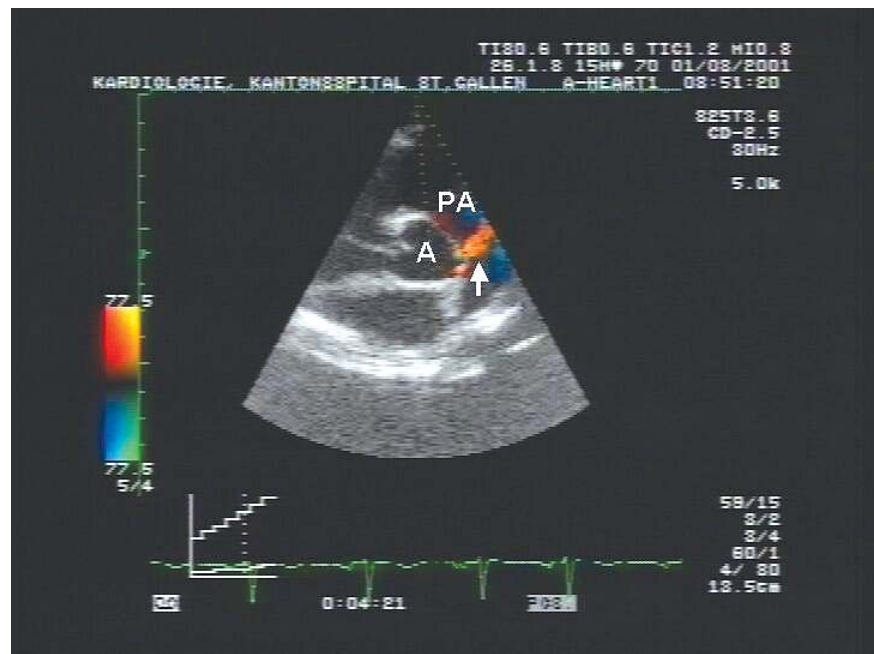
Transthoracic echocardiogram (parasternal short axis view) from the same patient showing an abnormal vessel entering the pulmonary trunk (arrow). In this patient, the diagnosis of anomalous origin of the left coronary artery from pulmonary artery was established by echocardiography before transfer to a catheterization center. A=aorta; PA=pulmonary artery
